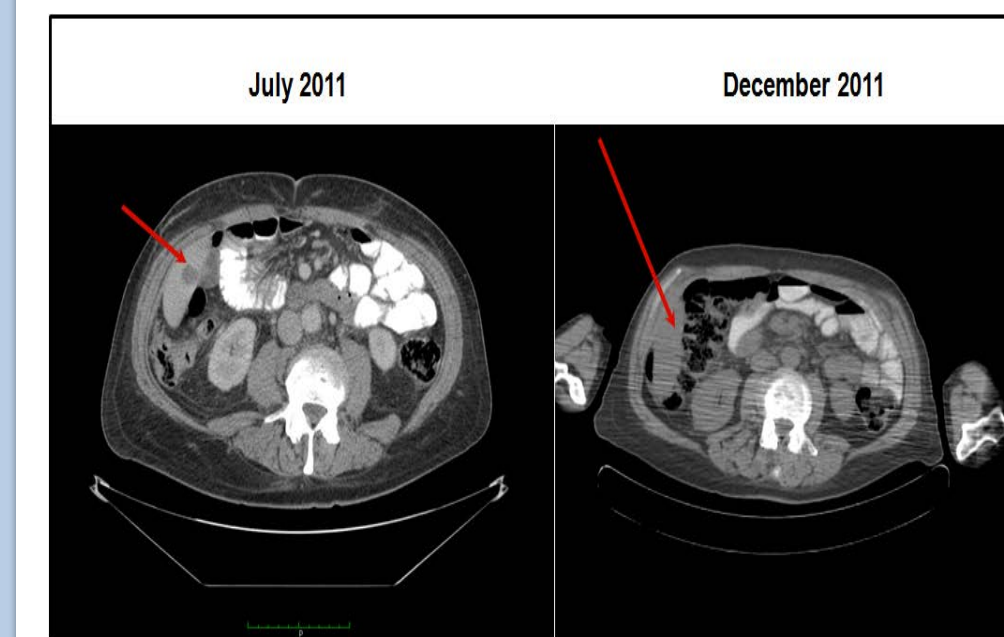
Case report #1. Patient treated with algenpantucel-L 4 mos before recurrence (liver mets by CT/PET and elevated CA19-9). Subsequent treatment: FOLFIRINOX with complete radiologic (CT/PET) and biochemical response.
